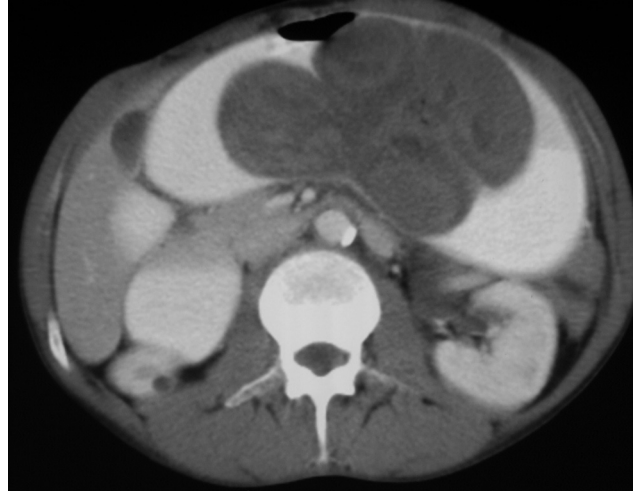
Abdominal CT showing jejuno gastric intussusception.
